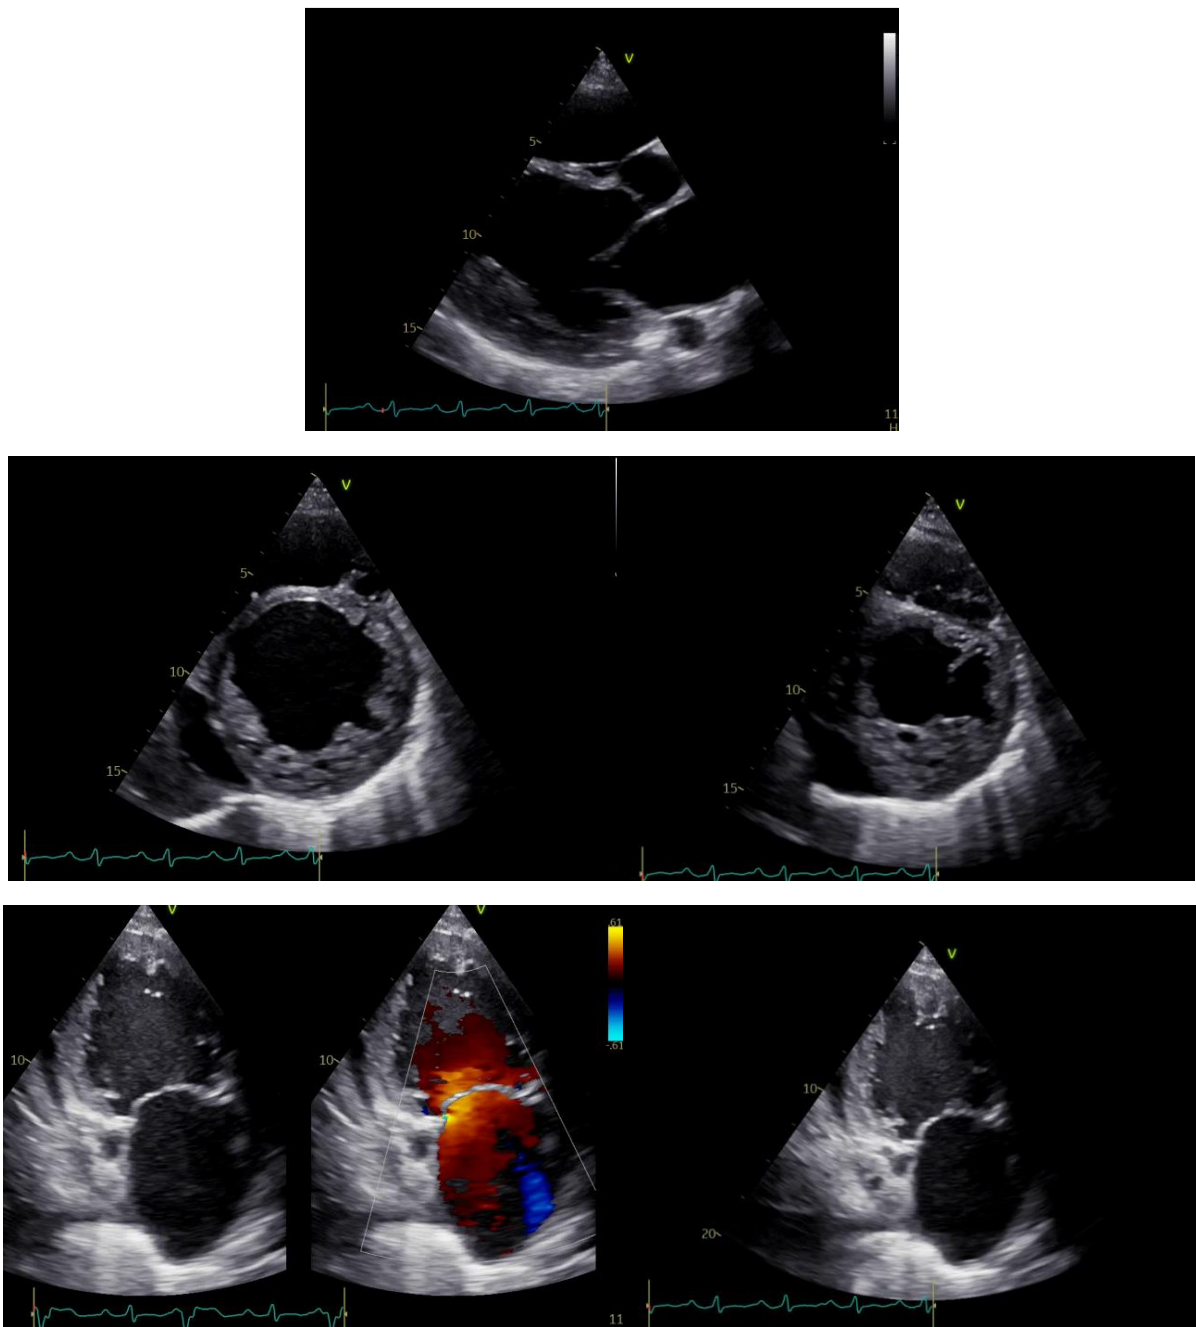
Echocardiography shows all chambers dilatation with global hypokinetic, low left ventricular ejection fraction, suspecting left ventricular non-compaction.
